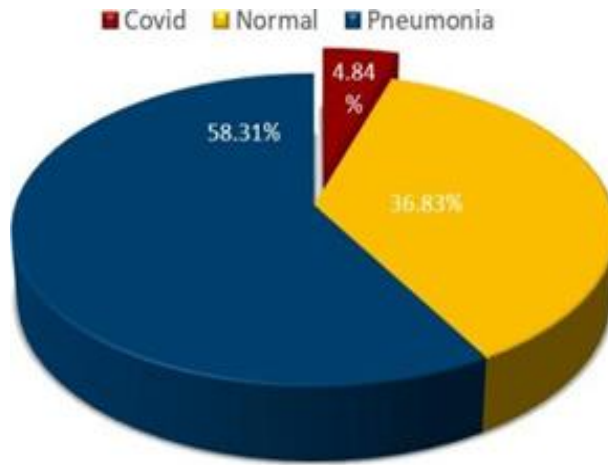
Statistical breakdown of chest radiographs
